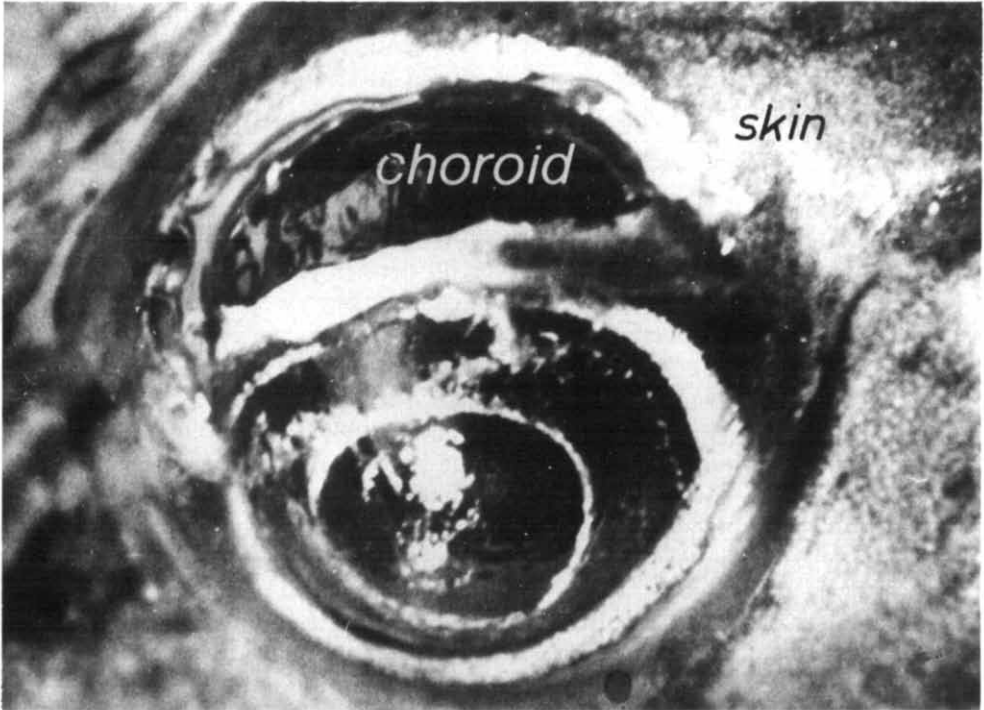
Frog eye after preparation for the X-ray experiment. The skin covering the eye and the sclera are dissected. The choroid of the upper part of the eye can be seen. Immediately adjacent to the choroid there is the retina with the rod outer segments.
